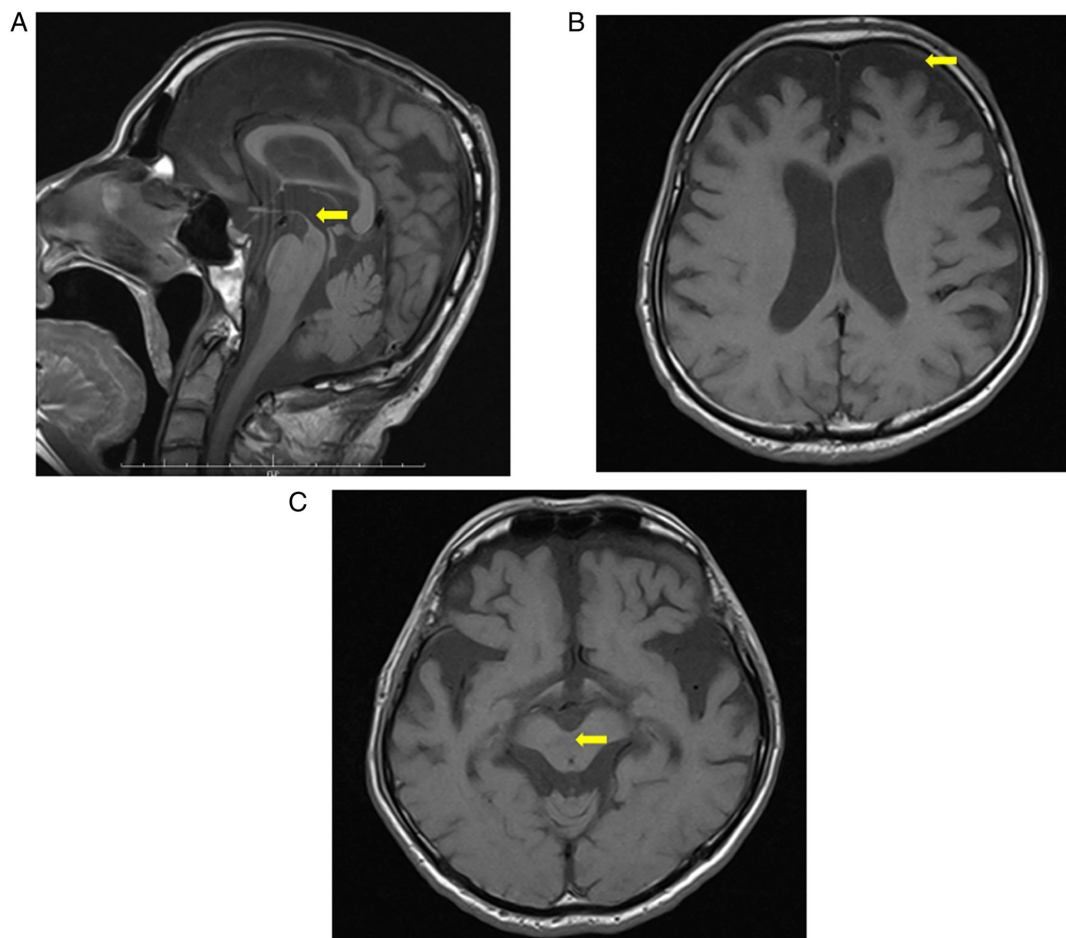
Brain MRI of the patient at 64 years of age (December 2017). Brain MRI shows (A) atrophy of the mesencephalic tegmentum (hummingbird sign), (B) atrophy of the frontal lobe and (C) atrophy of the mesencephalic tegmentum, which are characteristics of progressive supranuclear palsy-Richardson's syndrome. Arrows indicate the noted features. MRI, magnetic resonance imaging.
